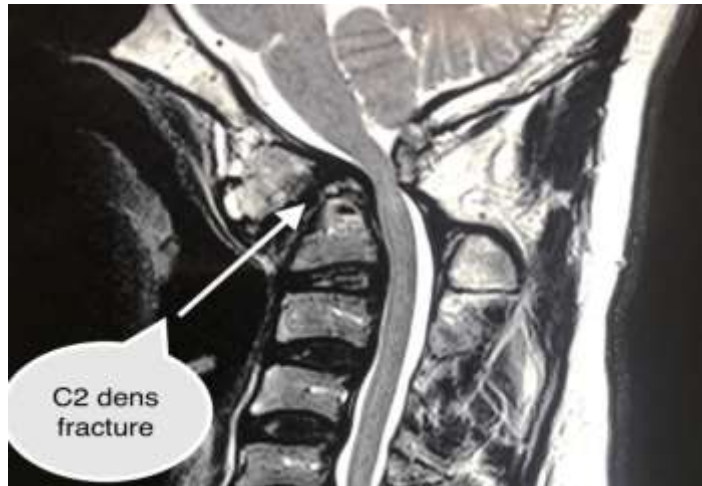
Sagittal MRI of the cervical spine showing severe stenosis at the C2 level with a neglected, displaced fracture of the odontoid process.
